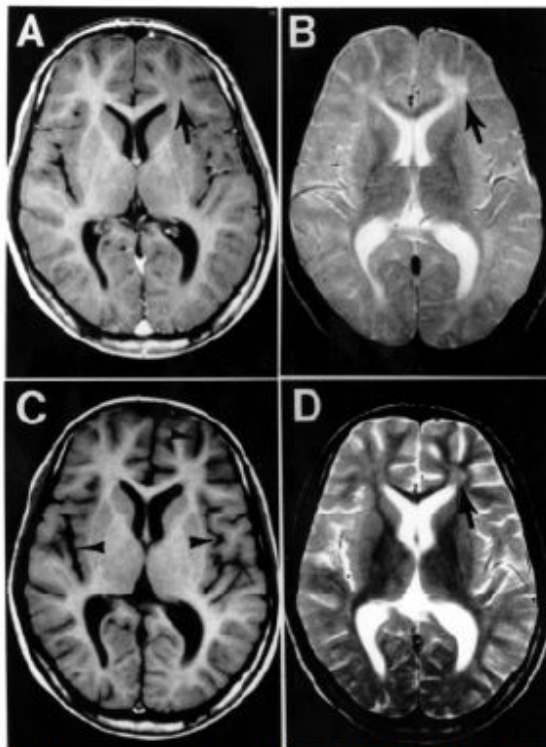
MRI scans of brain at time of presentation in the neurology clinic (A and B) and 3 months later (C and D). Panels A and C are T1-weighted images; B and D are T2-weighted images. The initial MRI scan (A and B) reveals a focal abnormality in the subcortical white matter of the left frontal lobe, consisting of a hypointense signal on the T1-weighted image (arrow in A) and a hyperintense signal on the T2-weighted image (arrow in B). In the follow-up scan, the focal abnormality in the left frontal lobe is less obvious than previously (arrow in D), but advanced and diffuse cortical atrophy is present, signified by the ventriculomegaly and markedly enlarged sulci (arrowheads in C).
